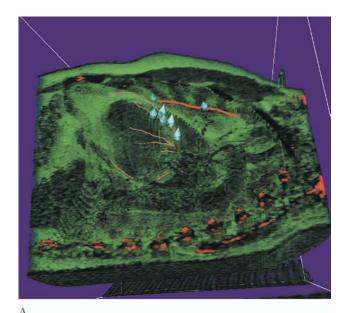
(A) Fiducials (see Appendix) markers positioned prior to the contrast computed tomographic (CT) scan on the patient's chest. (B) Segmented fiducials and patient skin from CT data. (C) Fusion of regions of interest isolated on the CT scan with the 3-D left coronary tree reconstructed (compare with Fig 2C).
